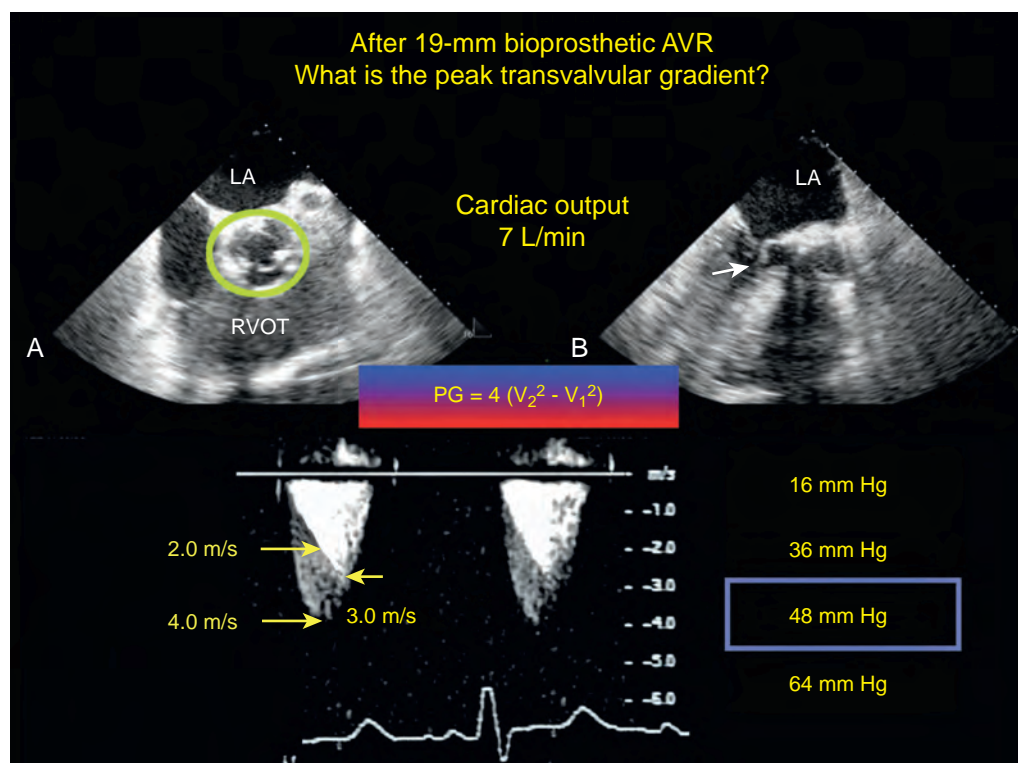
Normal aortic valve (AV) and left ventricular outflow tract (LVOT). Short- and long-axis views of the AV during systole. (A) Normally functioning 19-mm bioprosthetic aortic valve. (B) Narrowed LVOT. The continuous-wave Doppler profile shows two distinct flow profiles. The higher peaking profile is generated from the AV while the inner envelope is late peaking and due to dynamic LVOT obstruction. This presents a dilemma when assessing transvalvular gradient, since the subvalvular velocity is high enough it cannot be omitted from the Bernoulli equation. Although the peak velocity is 4 m/s (gradient 64 mm Hg), when considering the subvalvular flows, the more accurate gradient across the valve is closer to 48 mm Hg. Ao, aorta; AVR, aortic valve replacement; LA, left atrium; PG, pressure gradient; RVOT, right ventricular outflow tract.
